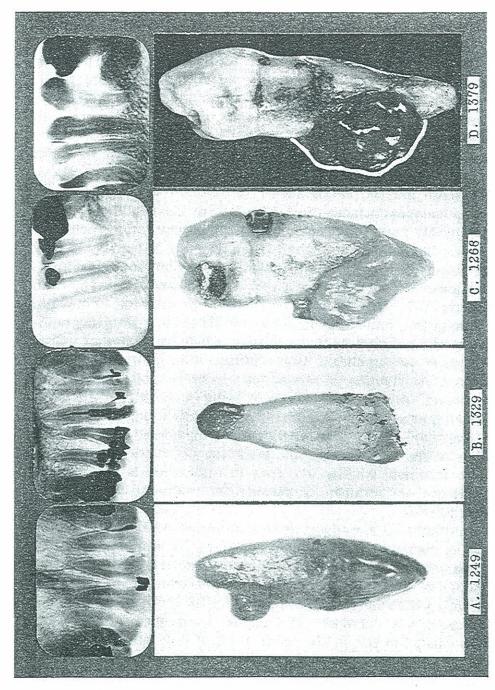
COMPARISON OF THE ROENTGENOGRAPHIC AND PHOTOGRAPHIC APPEARANCES OF EXTRACTED TEETII.
